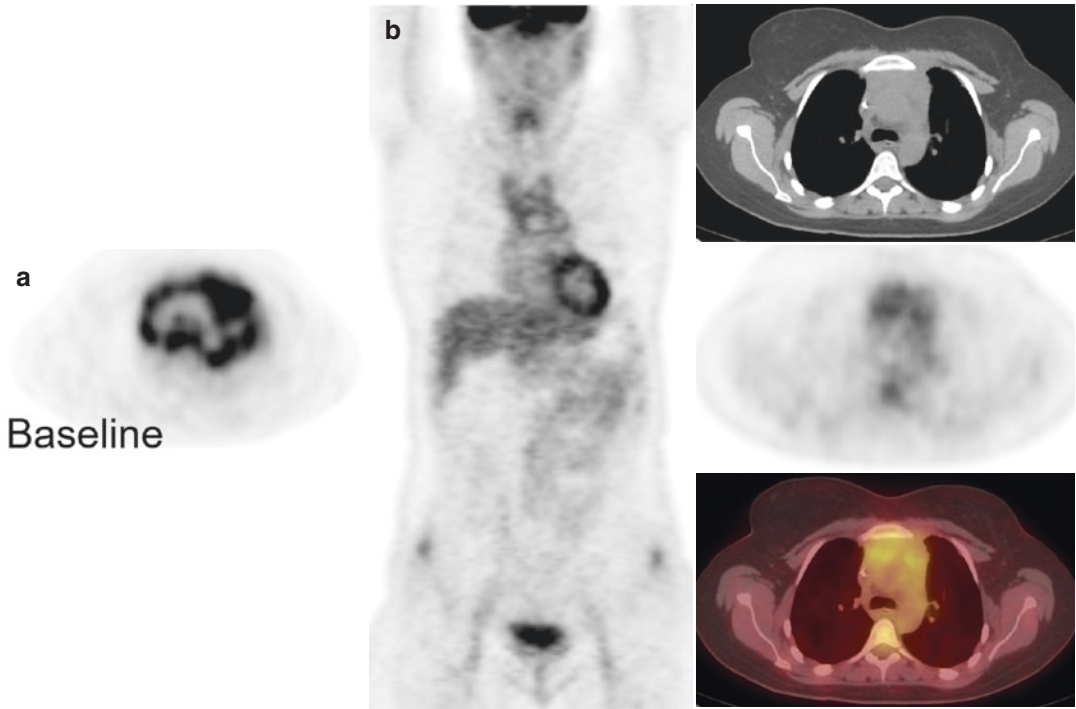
(a) Intensely FDG-avid primary mediastinal large B cell lymphoma in the neck and mediastinum prior to therapy. (b) End of therapy PET/CT scan showed FDG uptake greater than blood pool but similar to the liver in the residual mediastinal mass. This is a Deauville 3
